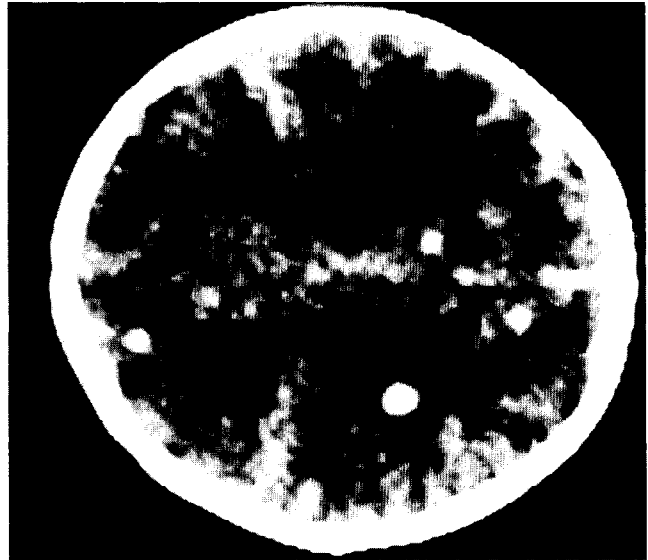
Computed tomography demonstrating several intracranial calcifications in a neonate
